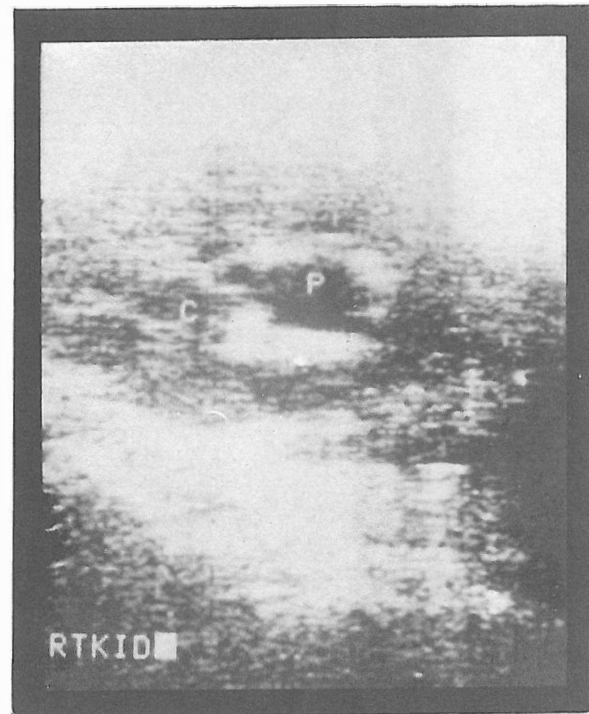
Ultrasonogram of a transplanted kidney with ureteral obstruction. Dilated pelvis and calyces are seen.
